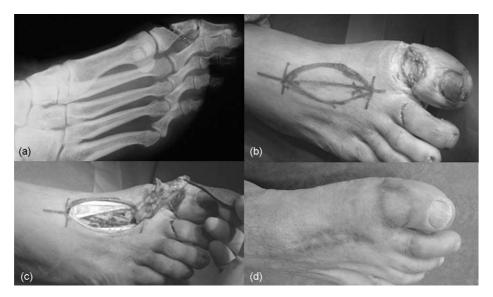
(a) The preoperative X-rays. (b) The 2.5 cm diameter loss of substance and the design of the flap $(2.5 \text{ cm} \times 5 \text{ cm})$. The X indicates the distal communicating artery. (c) The distally based islanded first web flap elevated with the distal communicating artery. (d) 2-years postoperative appearance.
